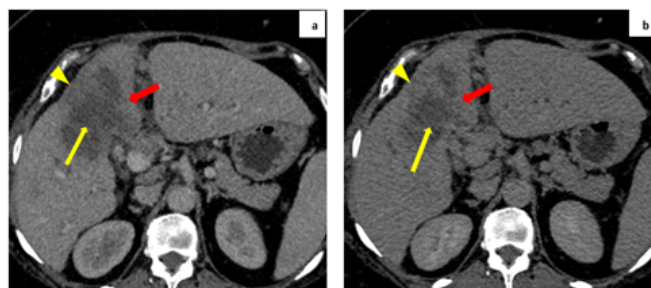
Intrahepatic mass forming cholangiocarcinoma: Axial sections of CT images in portal venous phase (a) and delayed phase (b) showing peripheral enhancement (red arrow) with central non enhancing area (yellow arrow) in segment V of right lobe of liver with adjacent capsular retraction (yellow arrow head).
